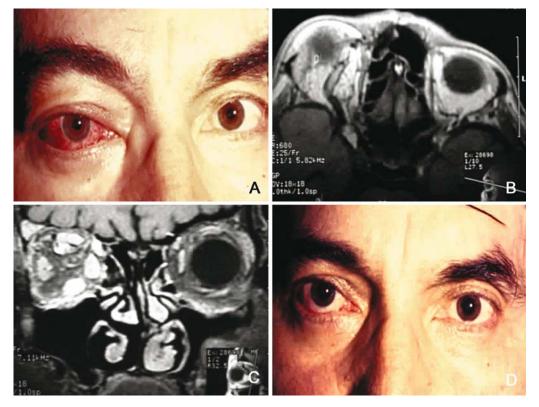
(A) Facial photograph of a 54-year-old man with carotid cavernous fistula affecting the right eye demonstrates the proptosis of the right eye and conjunctival and episcleral injection. The right eye had secondary glaucoma unresponsive to topical drops. (B) T1-weighted axial orbital MR image showing the dilated superior ophthalmic vein on the right side. (C) T1-weighted contrast enhanced coronal orbital MR image showing the equally enlarged extraocular muscles on the right side. (D) Postoperative appearance of the patient 2 months after balloon catheterization and closure of the fistula.
